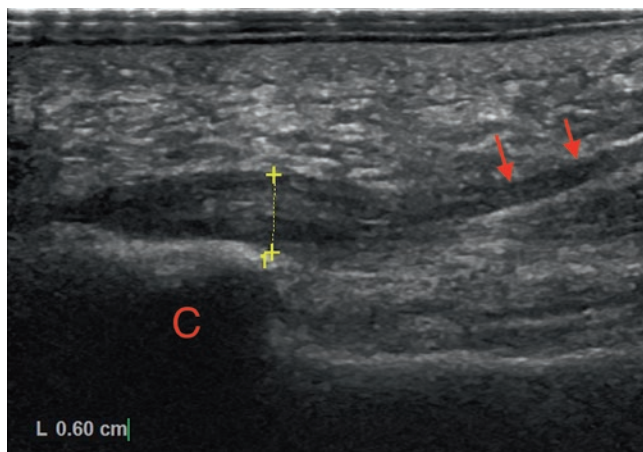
Plantar fasciitis. Long axis ultrasound shows a thickened low reflective plantar fascia at its calcaneal origin (between callipers). More distally the plantar fascia shows normal thickness (arrows). C = Calcaneus
